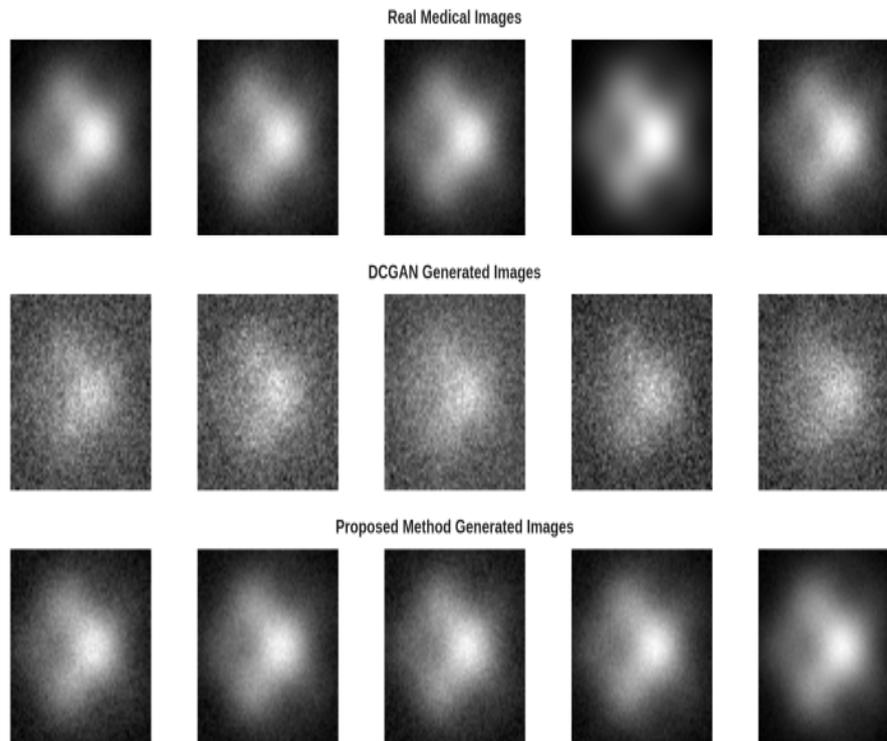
Comparison of real and synthetic medical images. The top row shows real chest X-rays, the middle row shows low-quality images from a baseline DCGAN, and the bottom row shows high-quality images from our proposed method.
